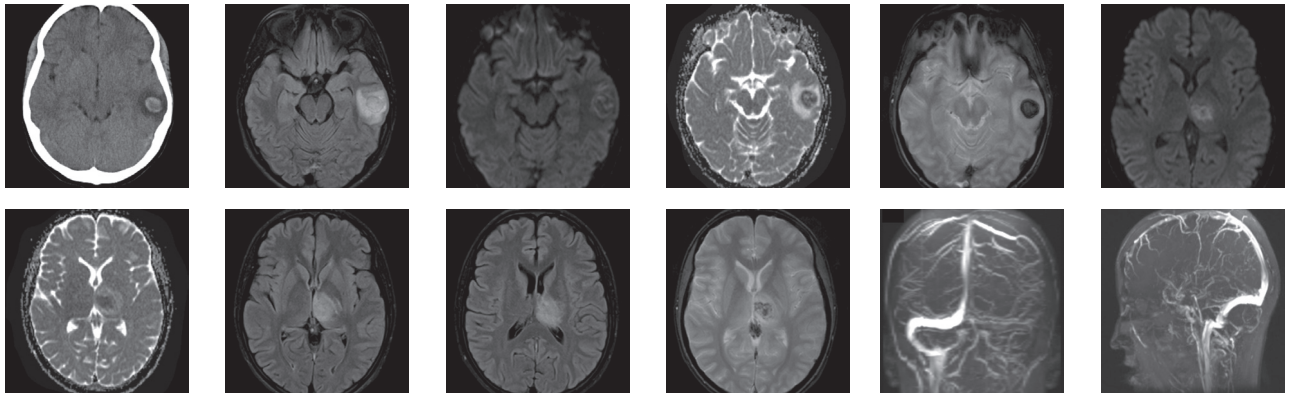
CT scan demonstrates intracerebral haematoma in the left temporal lobe (A). MRI scans were taken 6 days after the second CT scan. Left temporal lobe lesions depicting stroke and secondary hemorrhage in T2W/FLAIR, DWI, ADC map and T2W/Hemo images (B to E). Left thalamus and posterior limb of the internal capsule shows ischemic lesions with secondary hemorrhages in DWI, ADC map, T2W/FLAIR and T2W/Hemo images (F to J). TOF venography revealed filling defects in left transverse, left sigmoid and straight sinuses (K, L).
